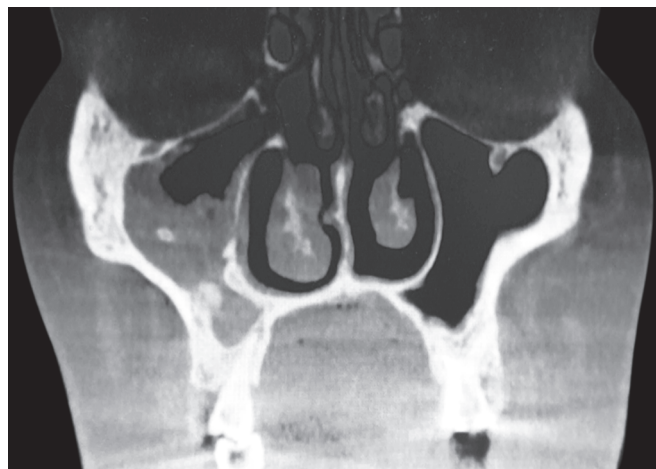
Coronal view of the CBCT showing the thickening of sinus mucosa with filling of the alveolar recess
